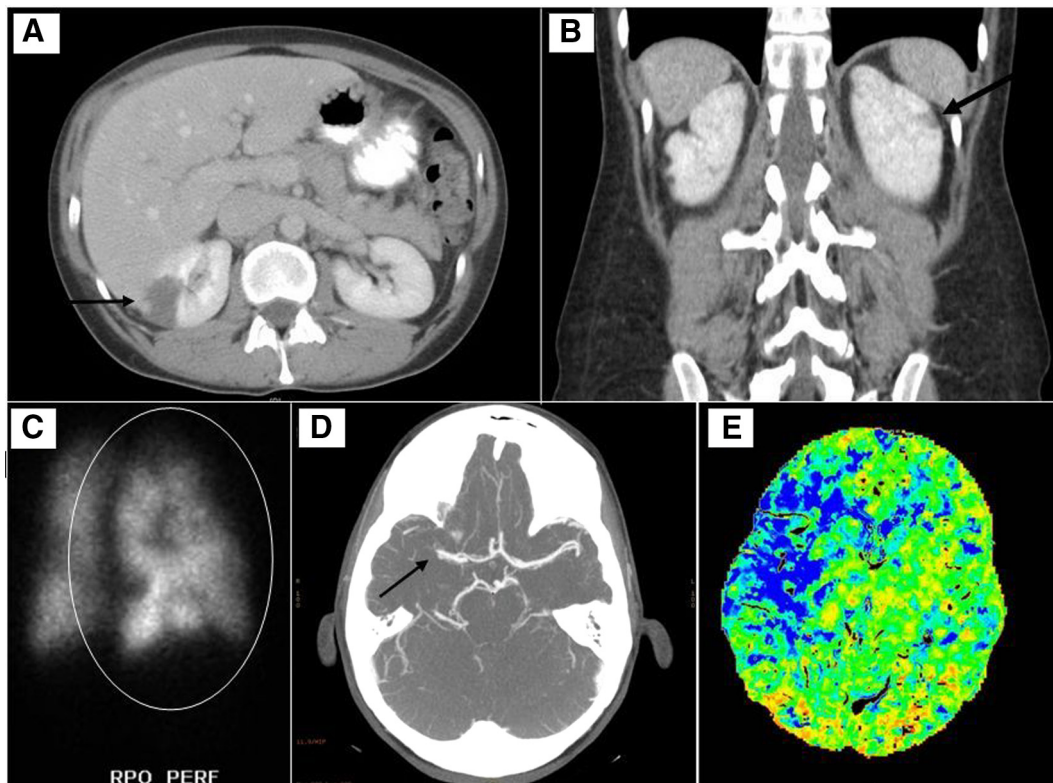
(A) An axial computed tomography scan showing a wedge-shaped infarct in the right kidney from the first thromboembolic event. (B) A coronal computed tomography scan showing a wedge-shaped infarct in the left kidney from the second thromboembolic event. (C) A ventilation-perfusion scan showing clear peripheral defects in the right lung from the third thromboembolic event. (D) An axial computed tomography scan showing occlusion of the right middle cerebral artery from the fourth thromboembolic event. (E) An axial computed tomography perfusion scan of the brain showing an elevated mean transit time (blue), consistent with ischemic penumbra in the territory of the right middle cerebral artery.
